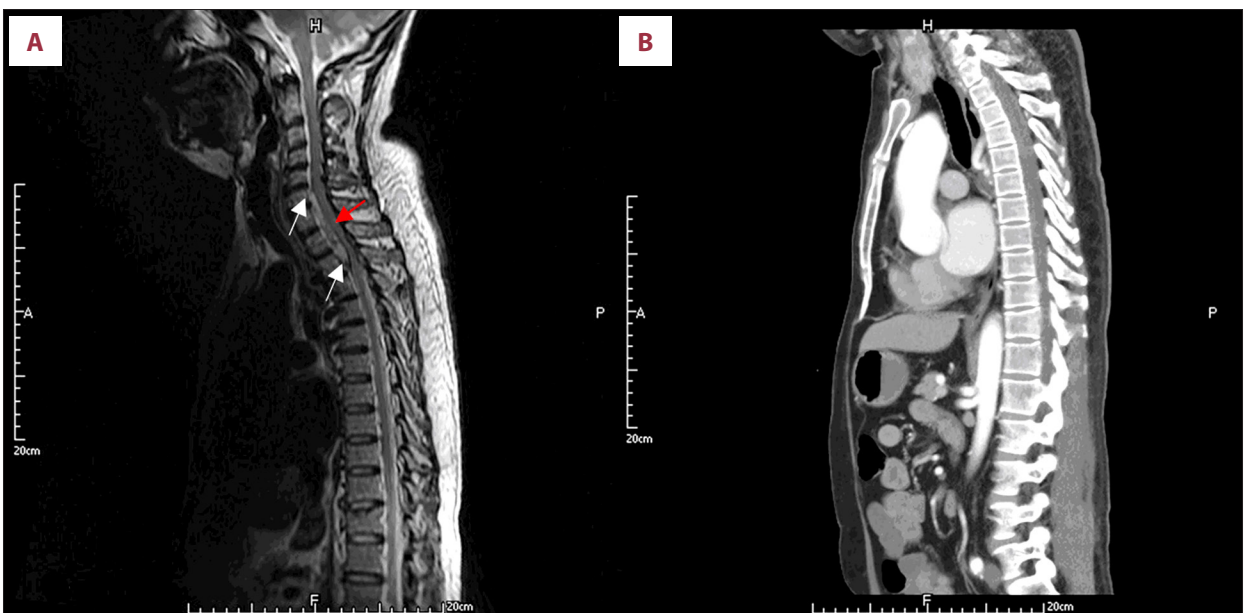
(A) A T2 phase sagittal view showing a fusiform lesion involving the anterior epidural space from C6 to T2 level (white arrow) and the squeezed medullary cord (red arrow). (B) Computed tomography angiogram sagittal view without obvious fusiform lesion over the same spinal level.
